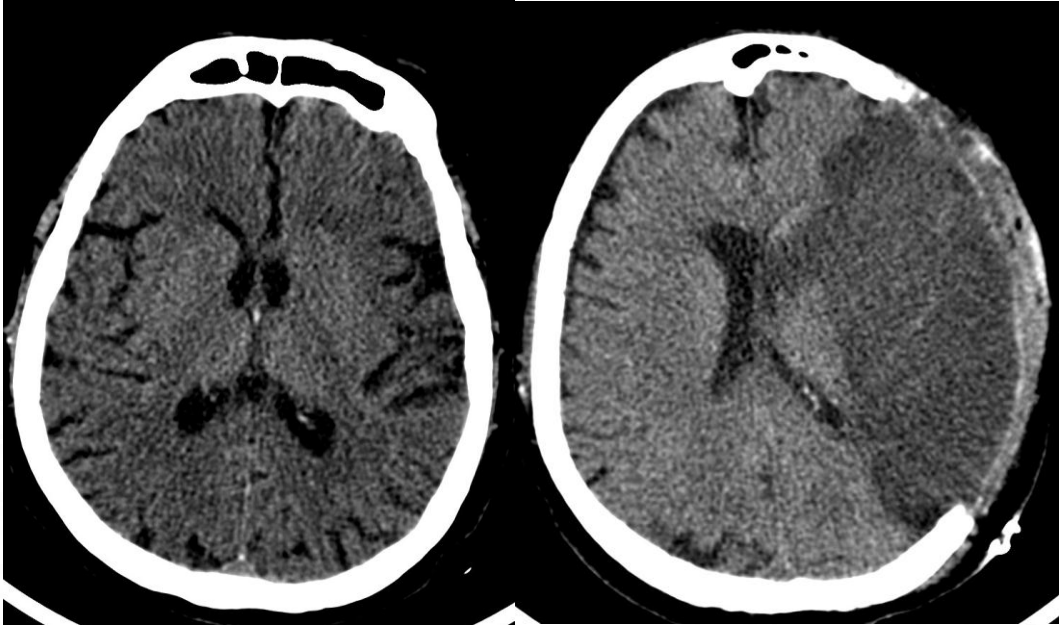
Plain CT Axial (ASPECTS 6)
